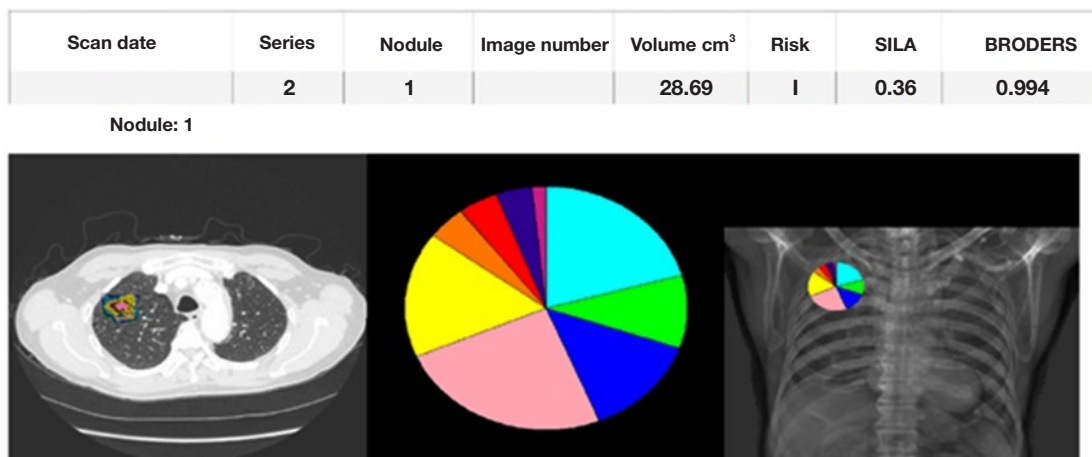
Example of CANARY analysis. Graphic example of nodule demarcation and CANARY analysis output. SILA, Computed Tomography-Based Score Indicative of Lung Cancer Aggression; CANARY, Computer-Aided Nodule Assessment and Risk Yield.
